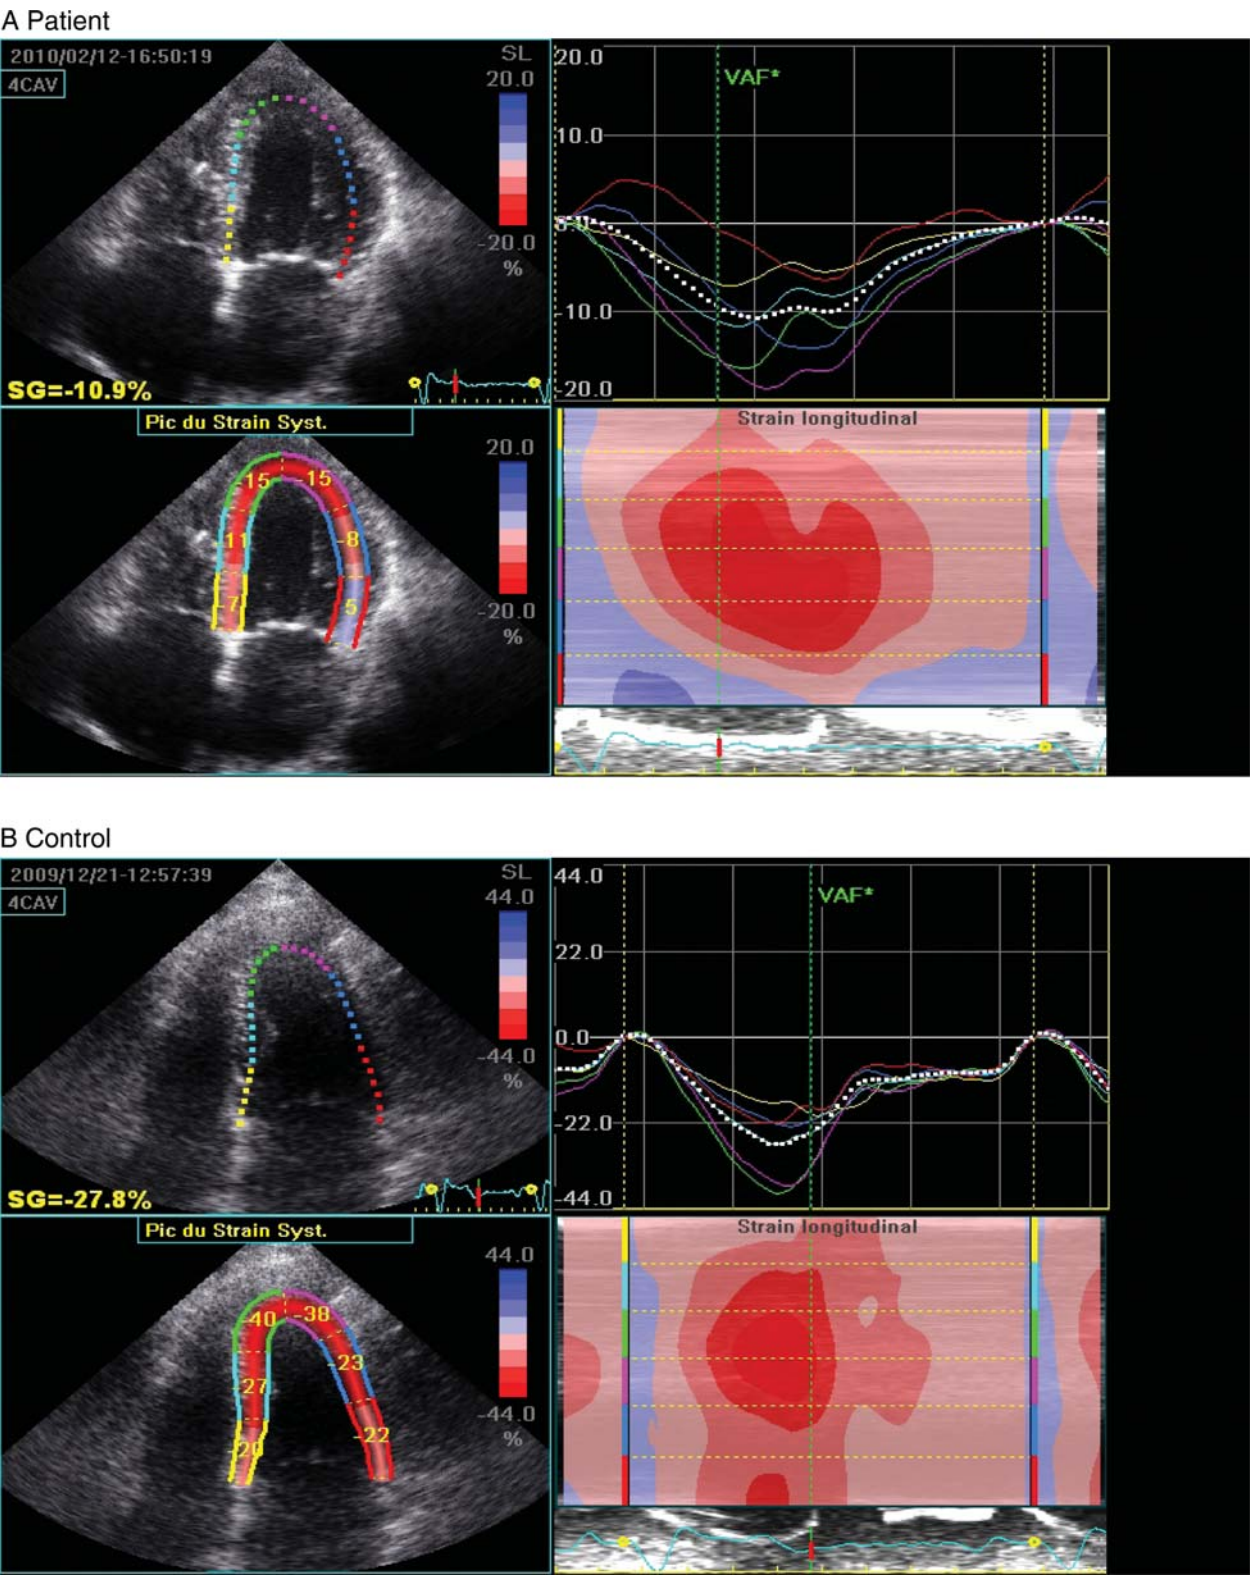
Two-dimensional strain in an apical four-chamber view in a patient with heart failure and preserved ejection fraction (A) and in a control patient (B).
